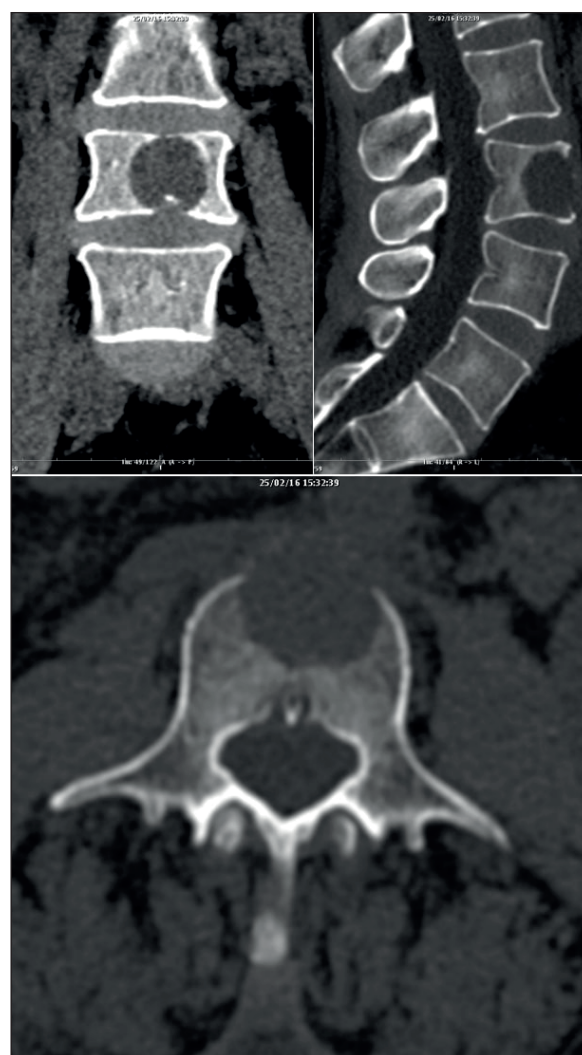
Hepatic carcinoma metastasis of L3. CT-Scan Images in coronal, sagittal and axial planes. The tumor is confined in the vertebral body. According to SINS score¹³, this is considered as unstable spine (TS: 8) so is advisable to perform a surgical posterior stabilization without decompression. In this tumor thermal-ablation is the gold standard treatment.
